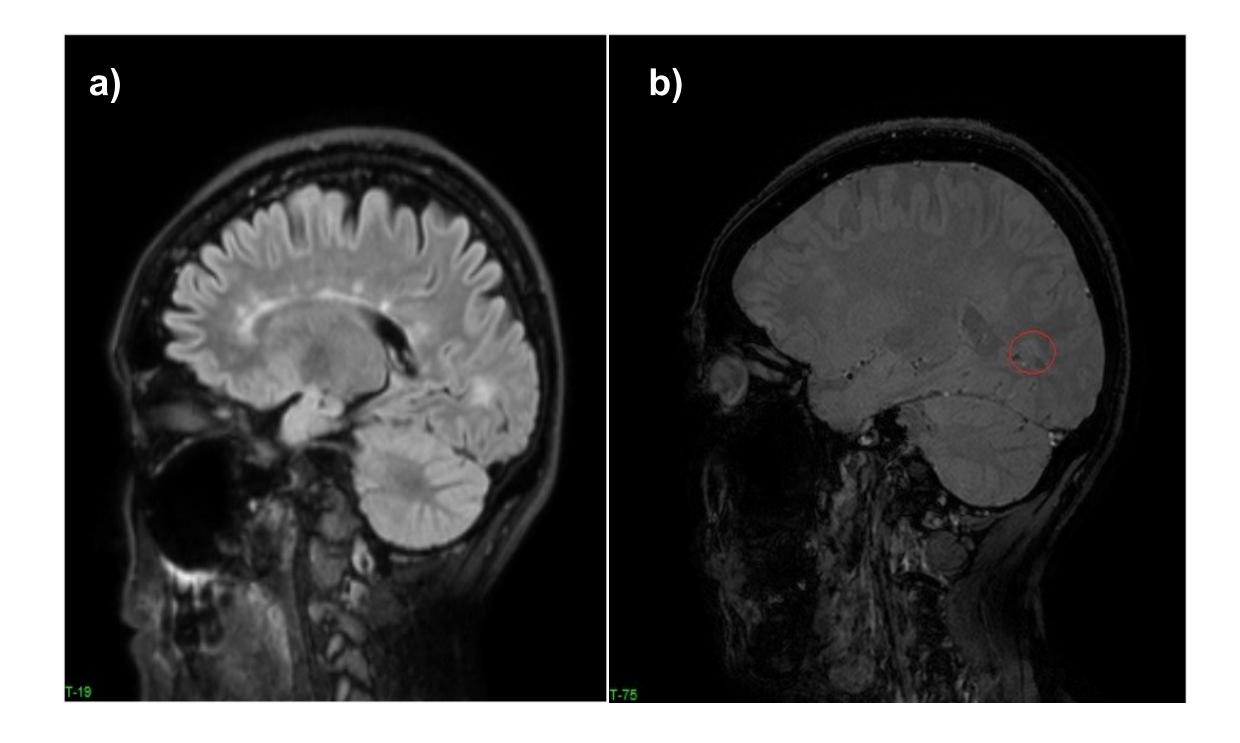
Lesion hyperintense on FLAIR presenting central vein sign on SWI. a) Sagittal FLAIR MRI scan showing an occipital lesion. b) ) Sagittal SWI MRI scan showing how this lesion presents the central vein sign (red circle).
